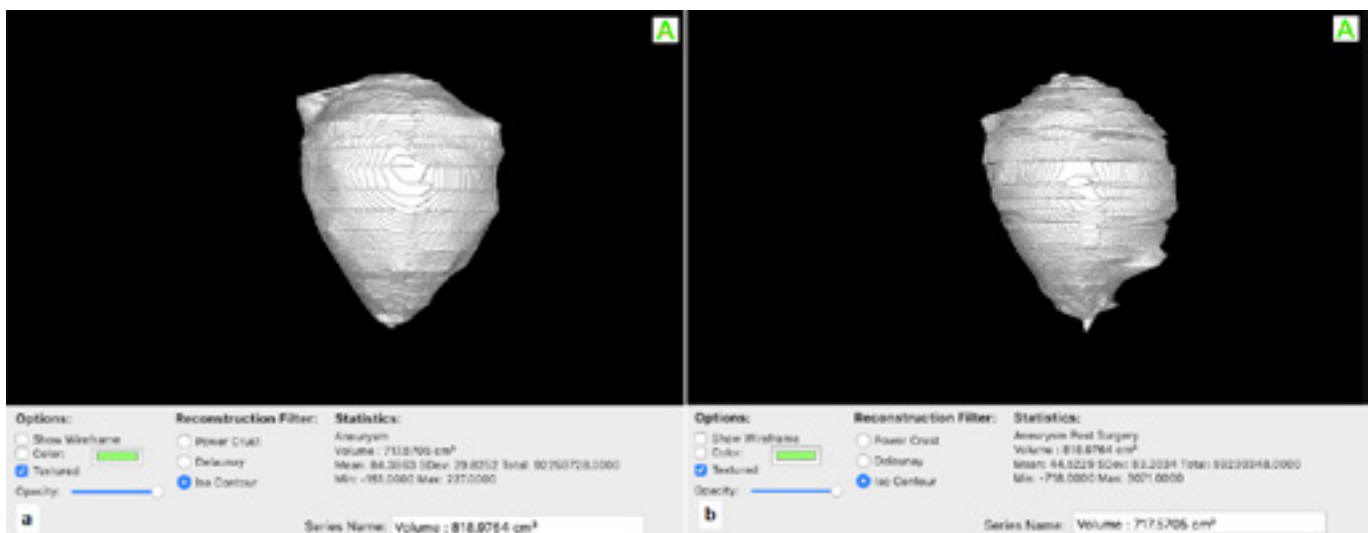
Segmentation of the false lumen common iliac aneurysm and comparison of the volume of the Region of Interest (ROI). a) On the preoperative CTA scan, the volume of the aneurysm is 818.97cm³. b) On the 9-month follow-up CTA scan, the volume of the aneurysm has considerably decreased at 715.57cm³.
